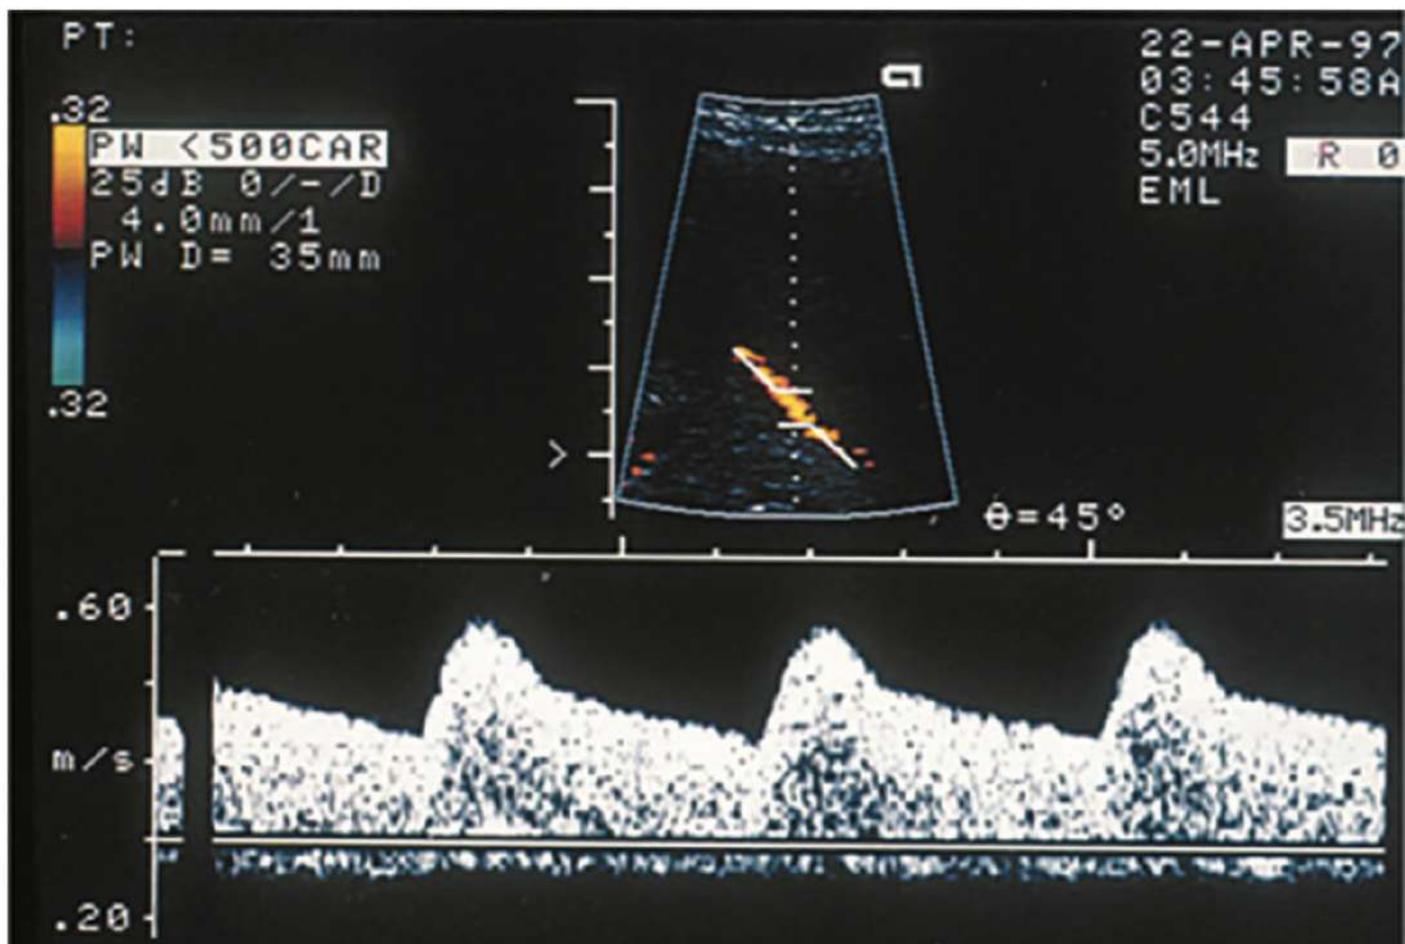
Normal umbilical arterial Doppler waveform.
